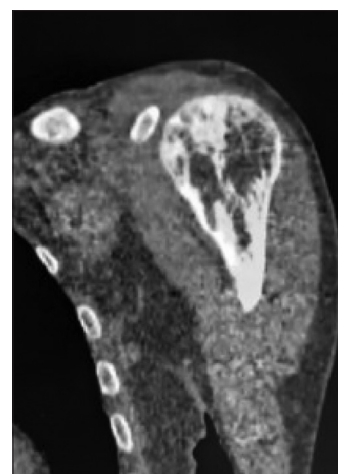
Computed tomography in the coronal section centered on the left shoulder showing multiple lytic lesions in the left humeral head
